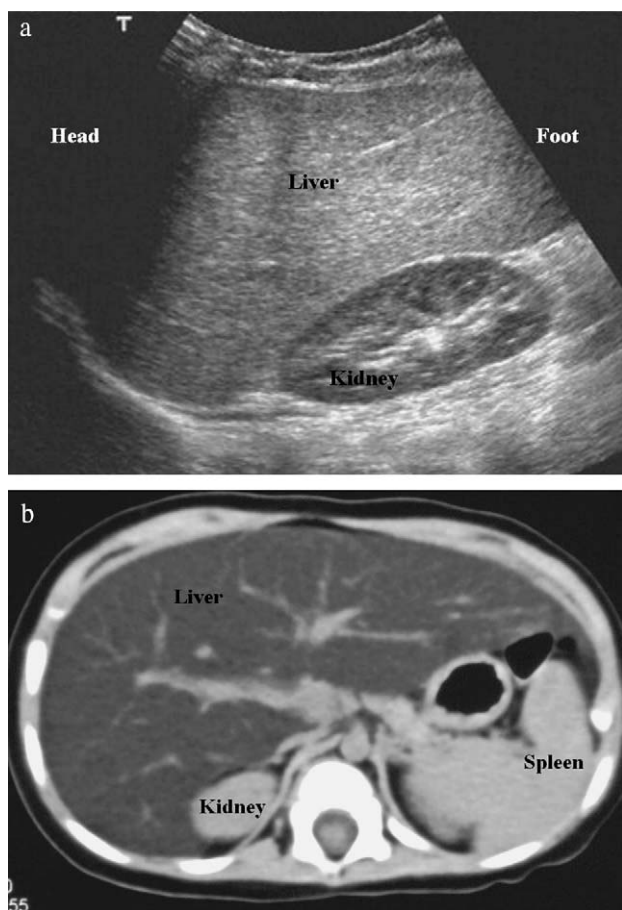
Citrin deficiency (newborn-onset adult-type citrullinemia type 2: CTLN2). (a) Homogeneous bright liver with mild hepatomegaly identified on ultrasonography. Liver/kidney contrast ratio was exaggerated. (b) Plain computed tomography indicated diffuse fatty infiltration.
